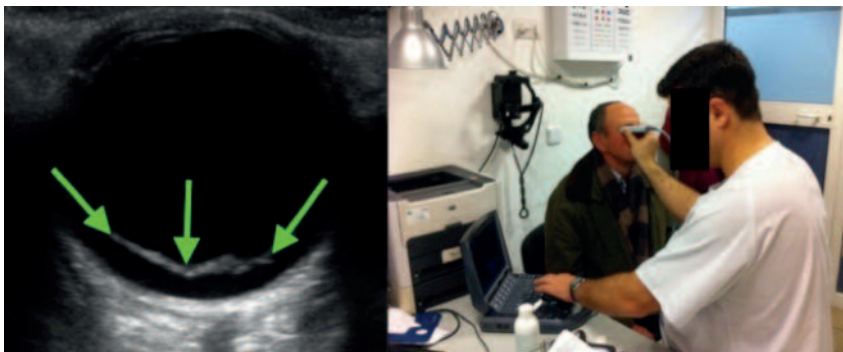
Left: ultrasound image of the right eye, showing an echogenic line (white), marked with green arrows, on the posterior eyeball, compatible with a detached retina (left). Right: Emergency physician performing ultrasound of the patient's right eye, who remains seated on suspicion of retinal detachment, as the decubitus position could increase the size of the detachment.
